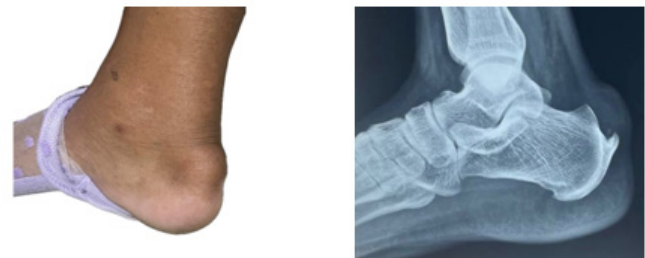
Clinical (left) and X-ray (right) picture of Insertional Achilles Tendinopathy with Haglund deformity
